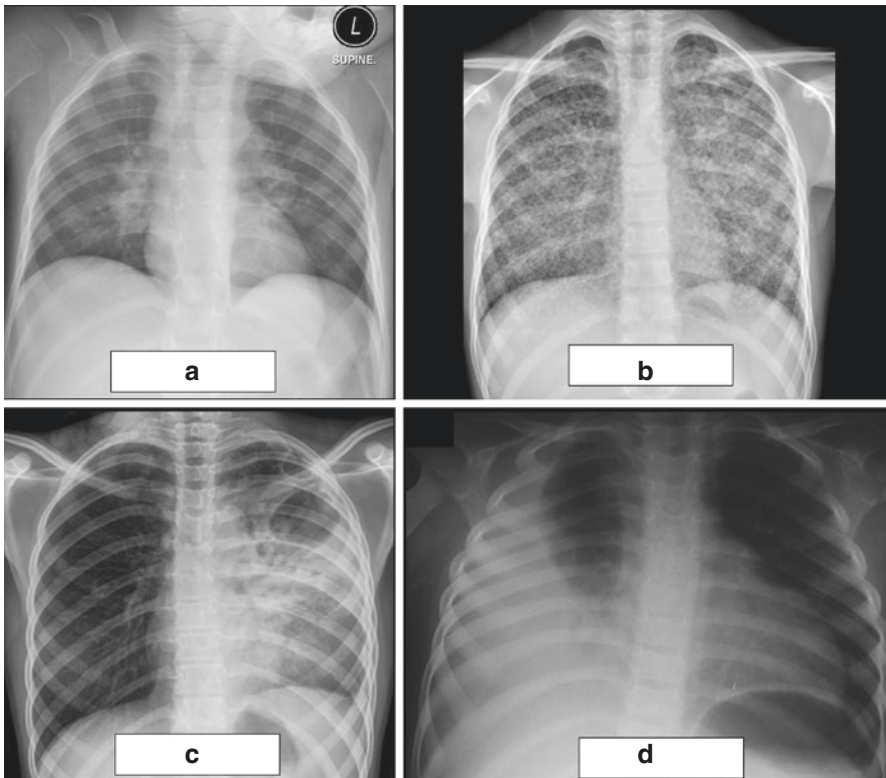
Chest radiograph images of children with features suggestive of tuberculosis. (a) Hilar lymphadenopathy (b) Miliary pattern (c) Cavities (d) Pleural effusion
